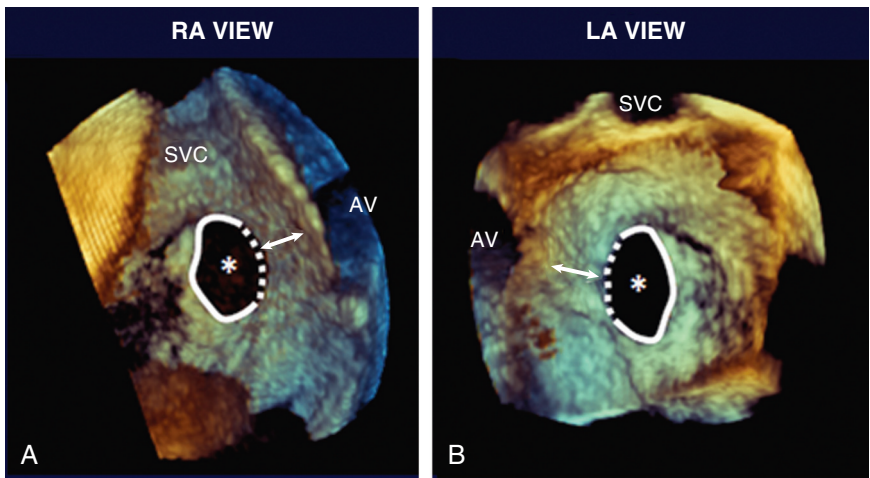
A, B, Assessment of ASD rims with three-dimensional echocardiography in the RA and LA views. The anterior rim is represented as the distance between the dotted line and the aorta (arrow). AV = aortic valve. (From Saric M, Perk G, Purgess JR, Kronzon I: Imaging atrial septal defects by real-time three-dimensional transesophageal echocardiography: Step-by-step approach. *J Am Soc Echocardiogr* 23:1128, 2010.)
